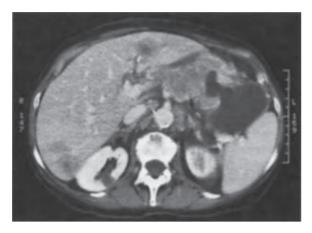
Hydro-multidetector row CT in a patient with advanced gastric cancer showing an advanced T3 tumour with local extragastric spread.
